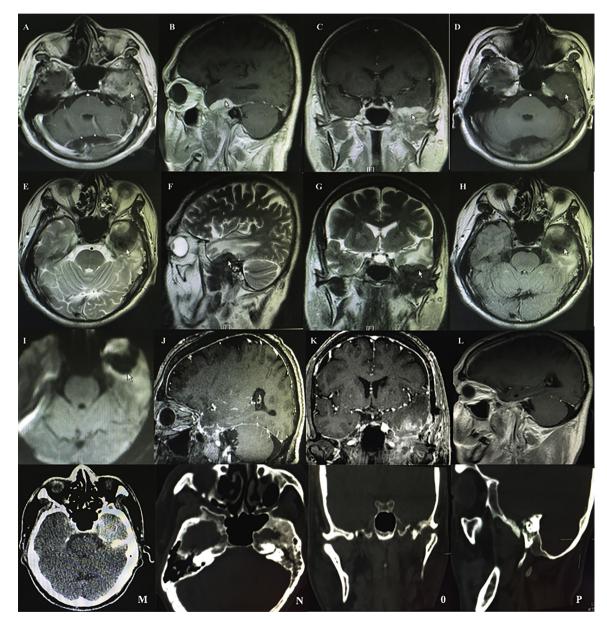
Brain MRI with contrast showed the enhancing lesion and the dural tail (A–C). T1 weighted MRI revealed the lesion to be iso-hypointense (D), and T2 (E–G) and FLARE (H) predominant hypointense and perilesion edema. DWI also showed circular hyperintense surrounding lesion and very hypointense for lesion (I). Non-contrast axial CT scan showed a homogeneously hyper-dense lesion without any internal calcifications and hemorrhage in the left middle cranial fossa base (M). Hyperplasia and destruction of skull base bone were seen according to three-dimensional CT scan (N–P). Post-operative MRI of the brain showed total excision of the lesion (J, K) and without evidence of recurrence after 5 years of follow-up (L).
